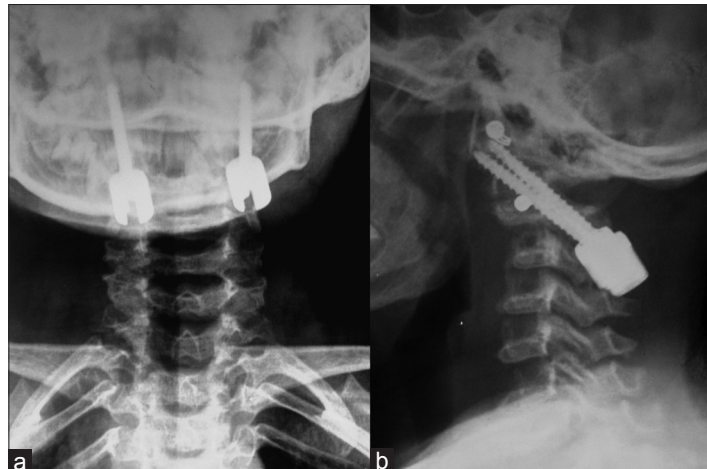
Anteroposterior radiograph of upper cervical spine (a) and lateral radiograph (b) at 24 months follow-up showing C1-C2 transarticular fixation
